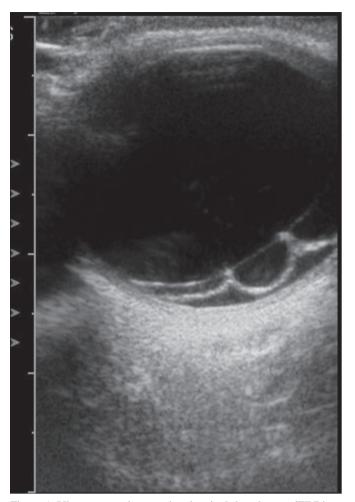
Ultrasonography: tractional retinal detachment (TRD)
